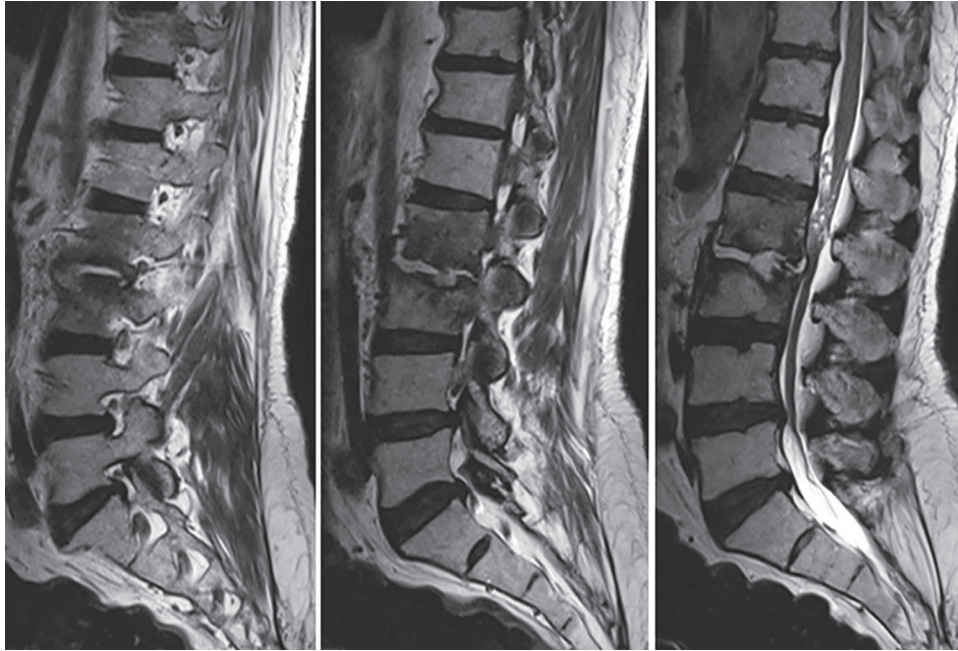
MRI T2 weighted sagittal image showing L2-L3 end plate enhancement with hyperintensity over disc space
